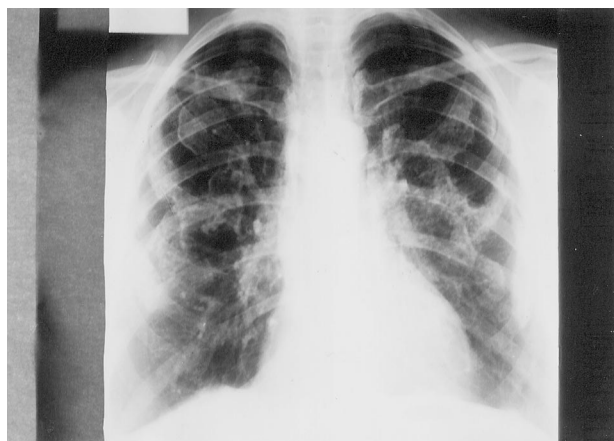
Chest radiograph of a Metsovite with extensive PCs.
